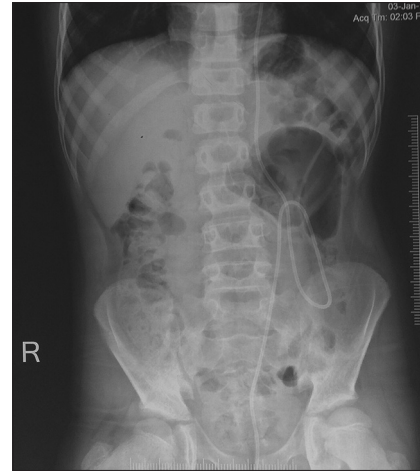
X-ray abdomen erect showing distal end of ventriculoperitoneal shunt tube going well beyond pubic symphysis
